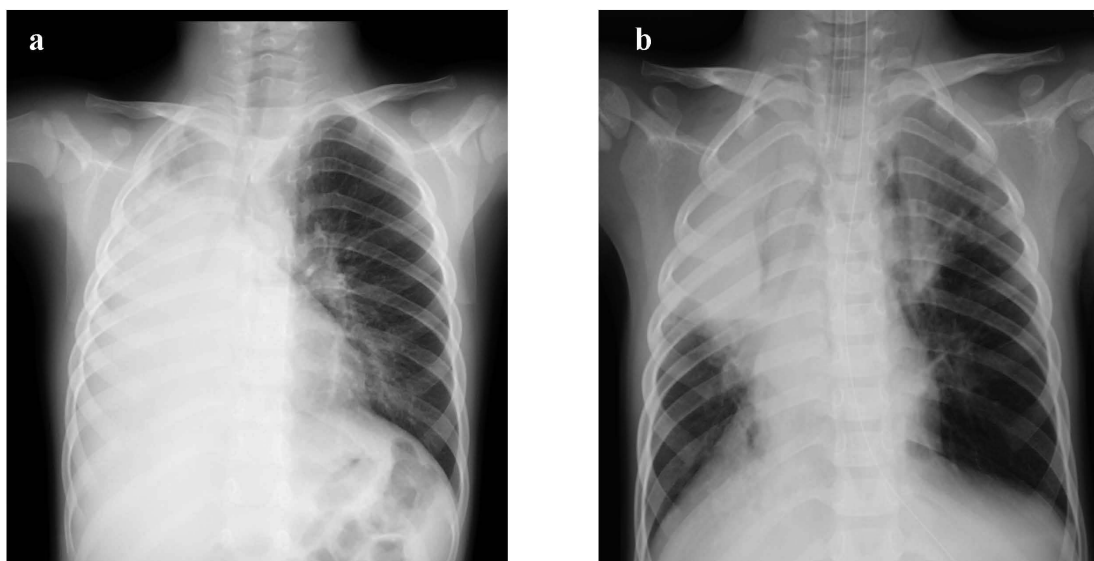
Chest X-ray images.
